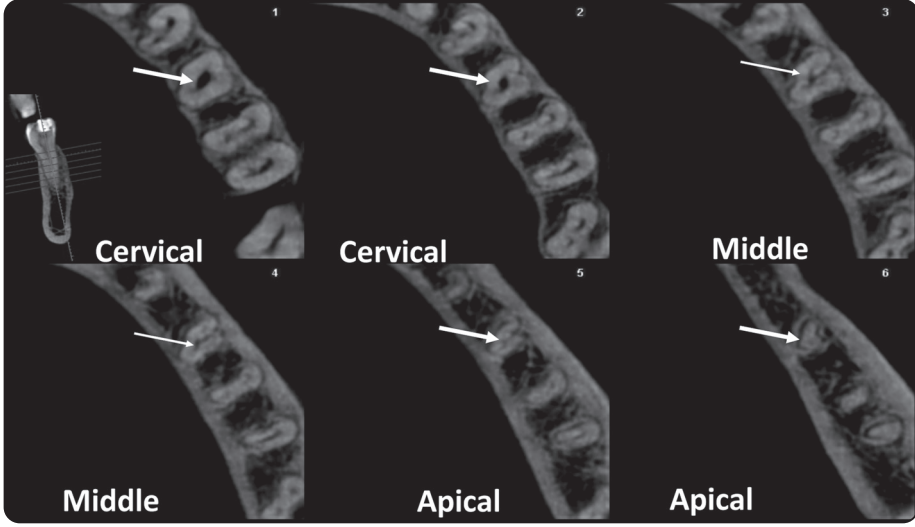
CBCT image of Lower left second premolar with serial axial cuts showing cross sections of C-shaped canal type C4 according to Fan’s classification in cervical, middle and apical parts of root.
